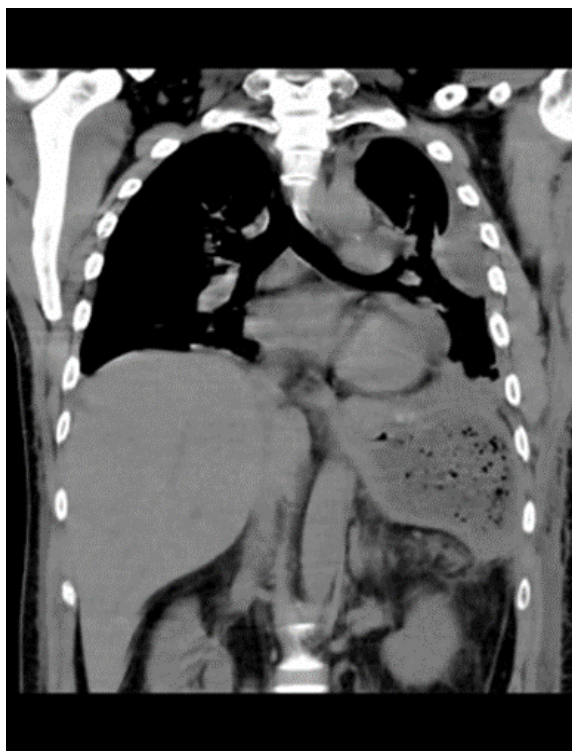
CT scan showed diaphragmatic rupture and intrathoracic bowel herniation
